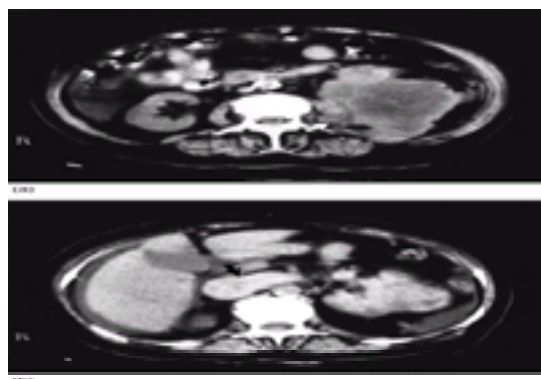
(a) CT section of the abdomen in a patient who presented with an abdominal mass due to carcinoma of the left kidney. Examination was obtained for tumour staging. The left kidney is replaced by an inhomogeneous mass which has obliterated the fat plane posterior to the kidney and infiltrated the left psoas muscle (arrow), indicating that the tumour is unresectable. (b) A section slightly higher shows tumour expanding the left renal vein and entering the inferior vena cava (arrow). Assessment of the renal vein is an essential component of tumour staging by CT.
